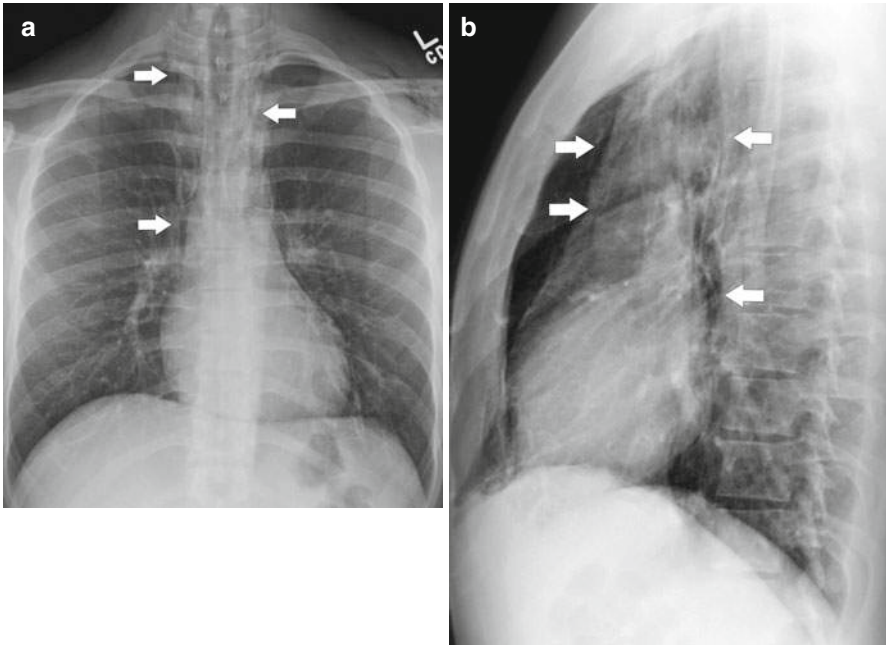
Pneumomediastinum. Chest X-ray posteroanterior (a) and lateral (b) views demonstrate linear lucencies (arrows) corresponding to mediastinal air
